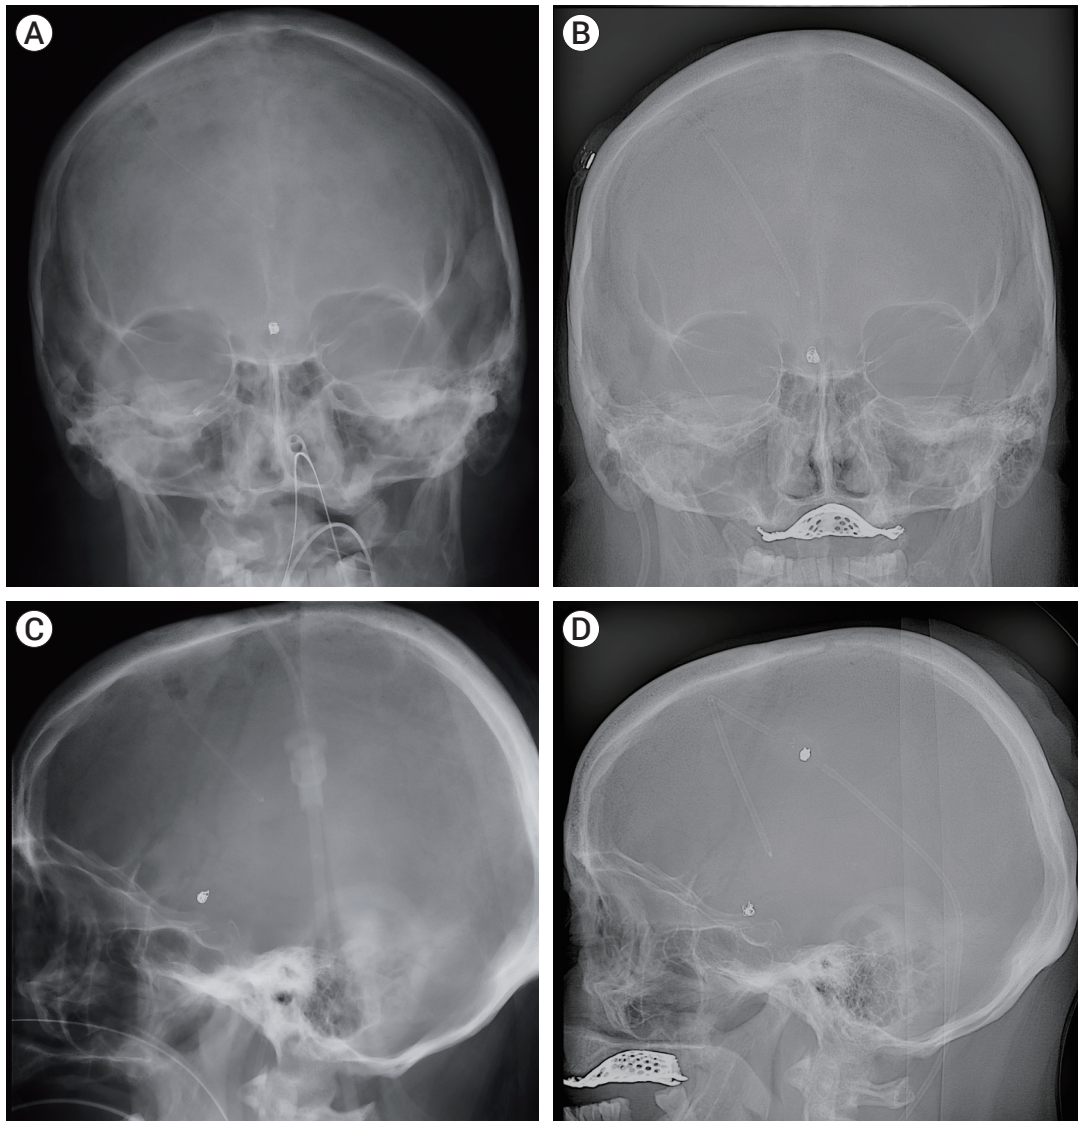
Acquisition of skull x-rays at the end of the coil embolization procedure (A, C) and at 6-month follow-up (B, D). Anteroposterior projection (A, B) was obtained with the patient looking straight to the front. A lateral projection (C, D) was obtained with alignment of the external auditory canals.
